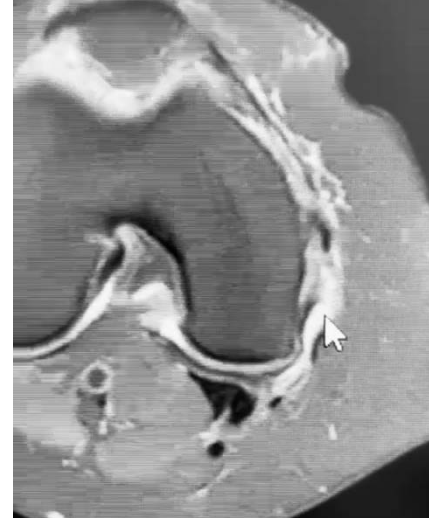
B: Postoperative MRI photographs showing, in the axial section, in addition to the swelling with stretching of the superficial and deep medial collateral ligament, the oblique posterior ligament.
